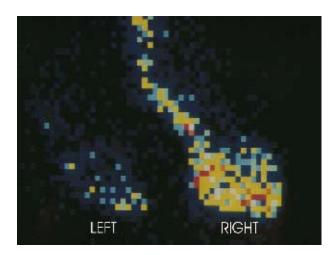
A scintigraphic study of the circulation of both front feet shows that the iced left foot has approximately 10-15% of the blood flow of the normal right foot (Photo Jan. Young).
